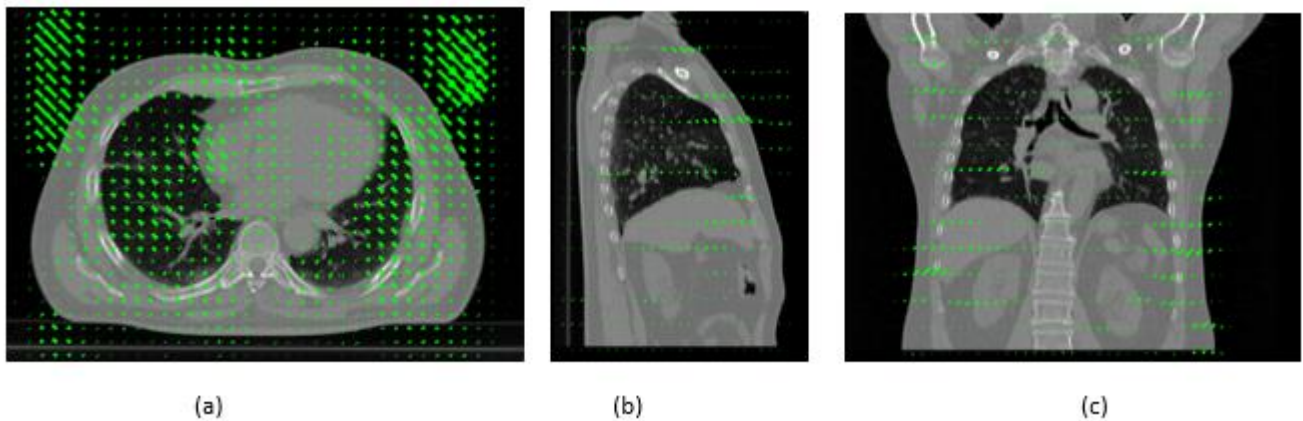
CT images of a lung case on which deformation field representing the system-dependent and patient-dependent geometric distortions in MRI is applied (a) axial plane view (b) sagittal plane view (c) coronal plane view
